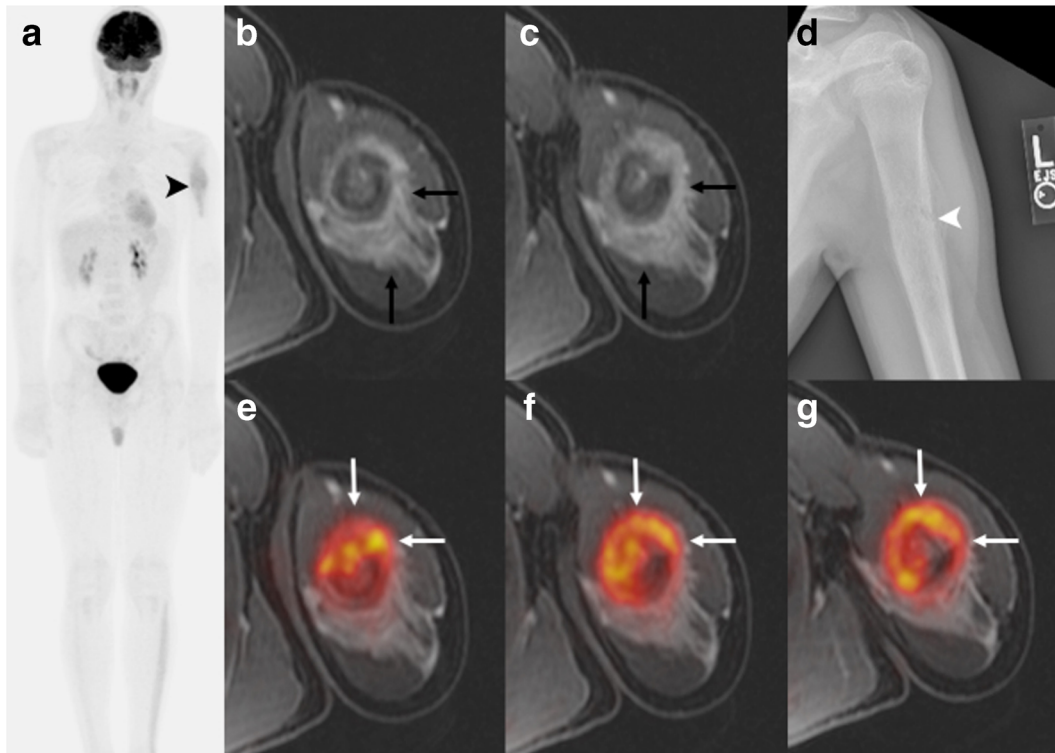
[^{18}F]FDG PET/MR and MR of the left humerus of a 14-year-old boy with Ewing sarcoma. a Maximum intensity projection [^{18}F]FDG PET of the whole-body showing increased FDG uptake of the tumor in the left humerus (*black arrowhead*). No skip lesions or metastases are noted. b, c Axial T1-weighted ferumoxytol-enhanced LAVA scan (TR/TE/Flip angle: 4.2/1.7/15) shows contrast-enhanced tumor and extensive perilesional edema (*black arrow*) d due to a pathological fracture (*white arrowhead*), confirmed on plain radiograph. e–g Axial [^{18}F]FDG PET superimposed on T1-weighted ferumoxytol-enhanced LAVA scan shows improved delineation of the tumor (*white arrow*) from enhancing peritumoral edema.
